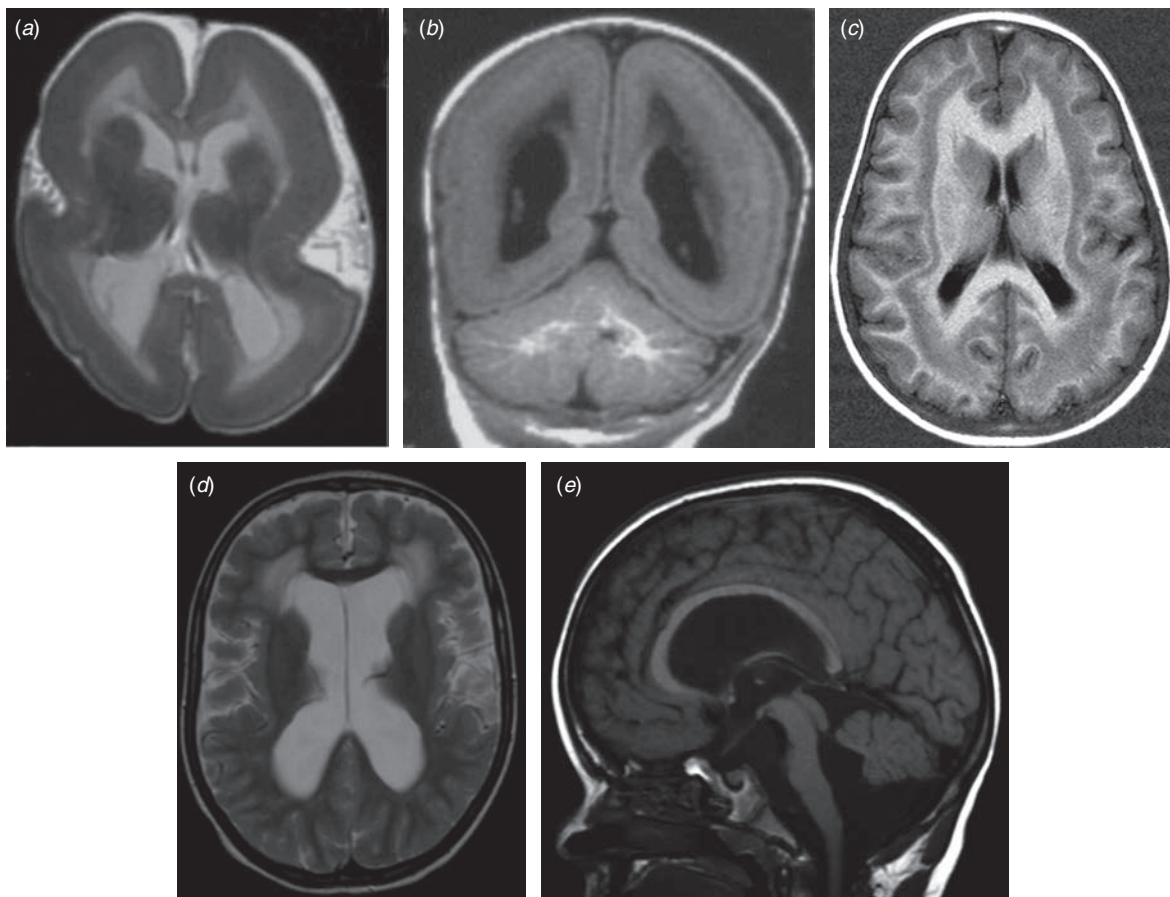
(a, b) Classic lissencephaly (*LIS1* gene mutation). T2-weighted brain magnetic resonance imaging (MRI; axial section) (a) showing agyria-pachygyria with anteroposterior gradient (anterior being more severe) and the classical figure-of-eight appearance of shallow sylvian fissures. T1-weighted brain MRI (coronal brain section) (b) showing the preserved cerebellum. (c) Classic X-linked lissencephaly caused by doublecortin (*DCX*) gene mutation. T1-weighted brain MRI (axial section) showing the subcortical laminar heterotopia with a thickened cortex and a rostrocaudal gradient. (d, e) Cobblestone lissencephaly. T2-weighted brain MRI (axial section) (d) showing pachygyria and polymicrogyria with anteroposterior gradient, and hydrocephalus. T1-weighted brain MRI (sagittal section) (e) showing brainstem and cerebellar hypoplasia.
